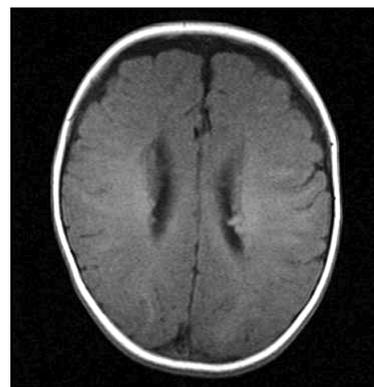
Magnetic resonance imaging showing tuberous sclerosis (typical calcified subependymal nodules).
